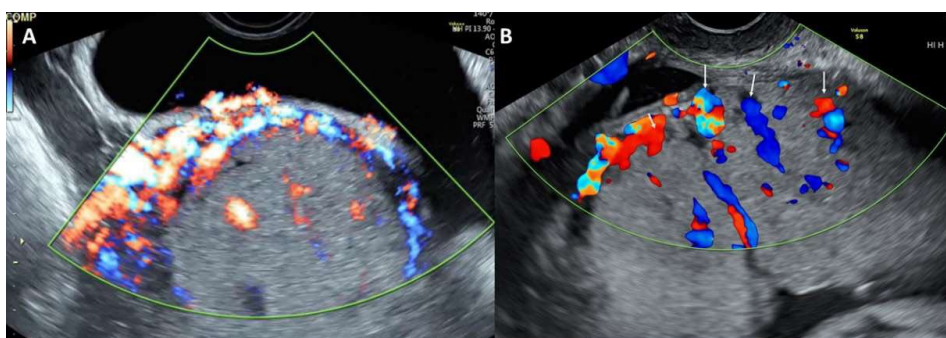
Colour Doppler image showing uterovesical hypervascularization (A) and the presence of bridging vessels (B).
